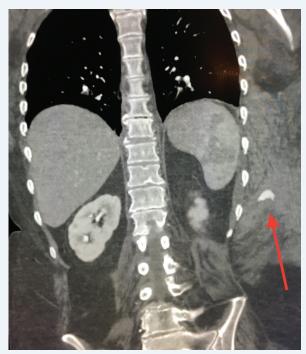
CT angiogram demonstrating active extravasation with a massive hematoma.
